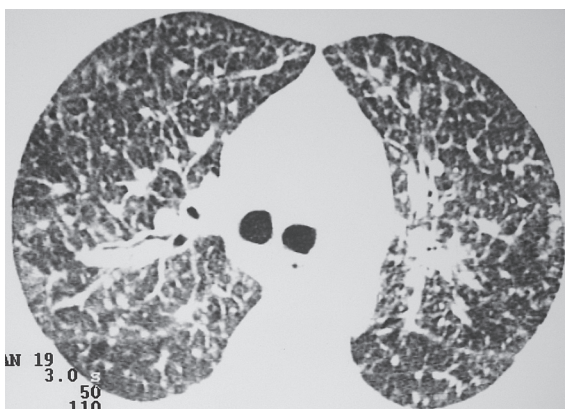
High-resolution computed tomography slice at the carina shows progression of the alterations described in Figure 1.
